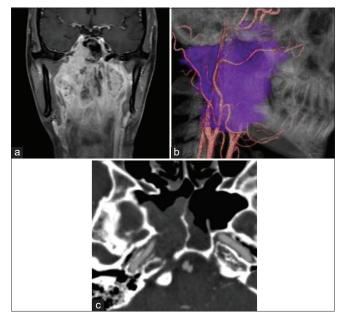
Preoperative images of the case. (a) Coronal gadoliniumenhanced T1-weighted magnetic resonance imaging shows that the tumor envelops the epipharyngeal region to the sphenoid sinus and the skull base. (b) Lateral view of fusion image between computed tomography angiography and tumor (purple color) reconstructions. Tumor engulfs the right side internal and external carotid arteries. (c) Computed tomography angiography reveals that the tumor envelopes the sphenoid sinus and the right side carotid canal. The bony structure of the carotid canal is dissolved by the tumor.
